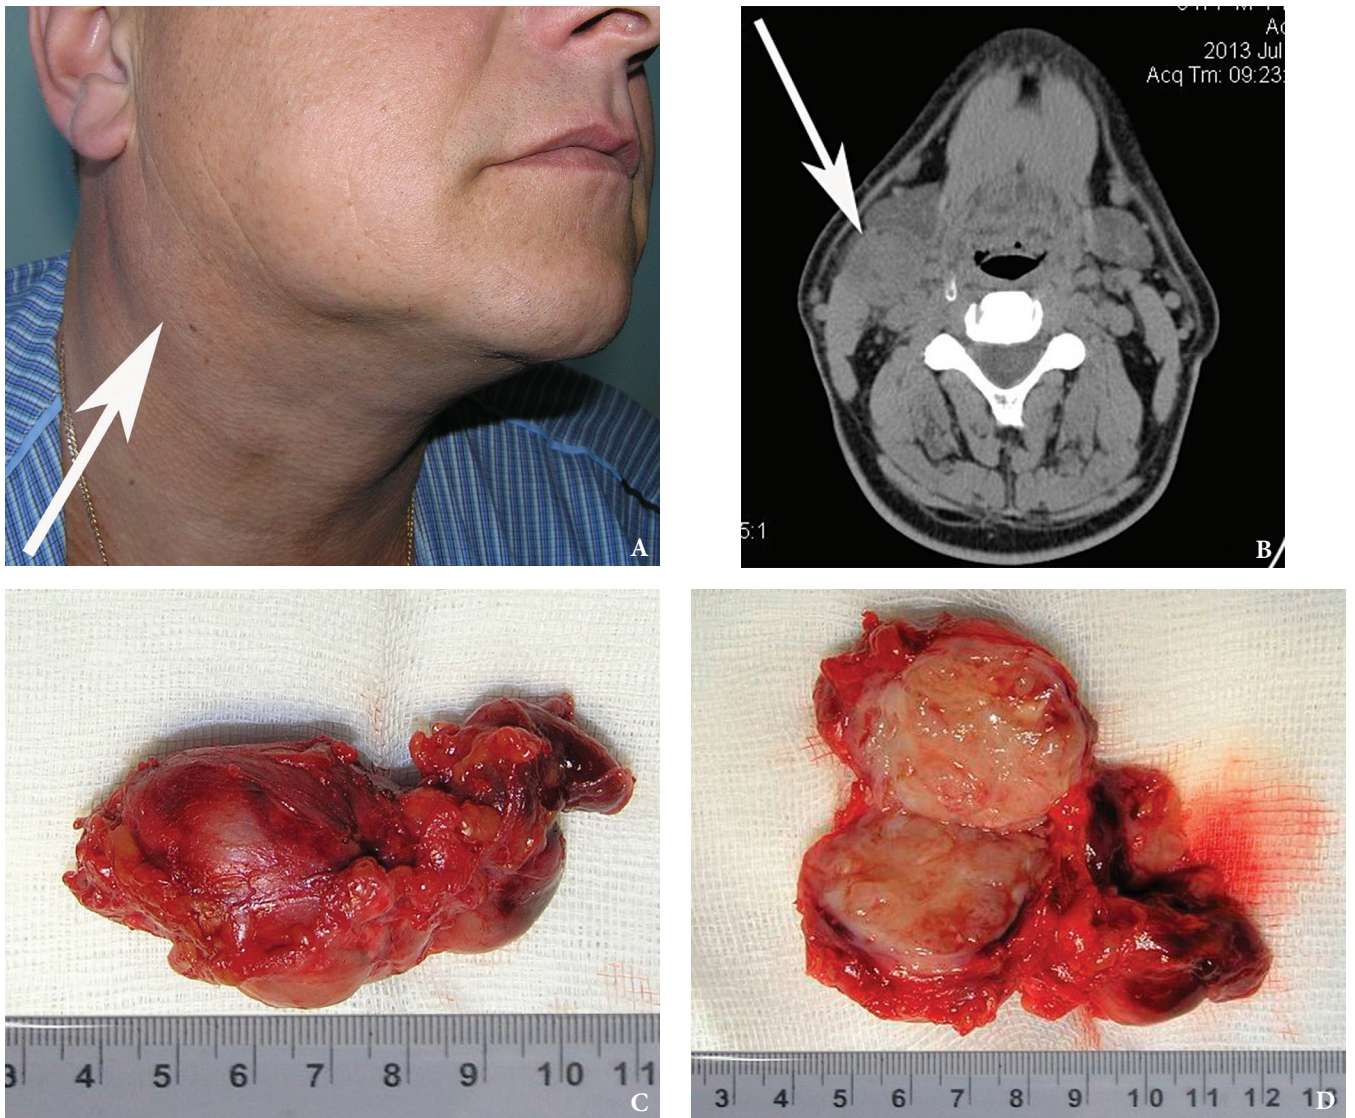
A patient with branchiogenic carcinoma (*arrow*) (A). Non-contrast CT image (B) shows the tumor (*arrow*). Tumor after its removal (C). Tumor on the section (D).
